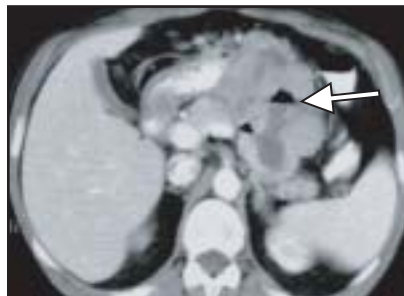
Small bowel GIST with central gas. CT demonstrates an exophytic mass with an irregular margin, heterogeneous contrast enhancement, and central gas within the tumor with a gas-fluid level (arrow).
